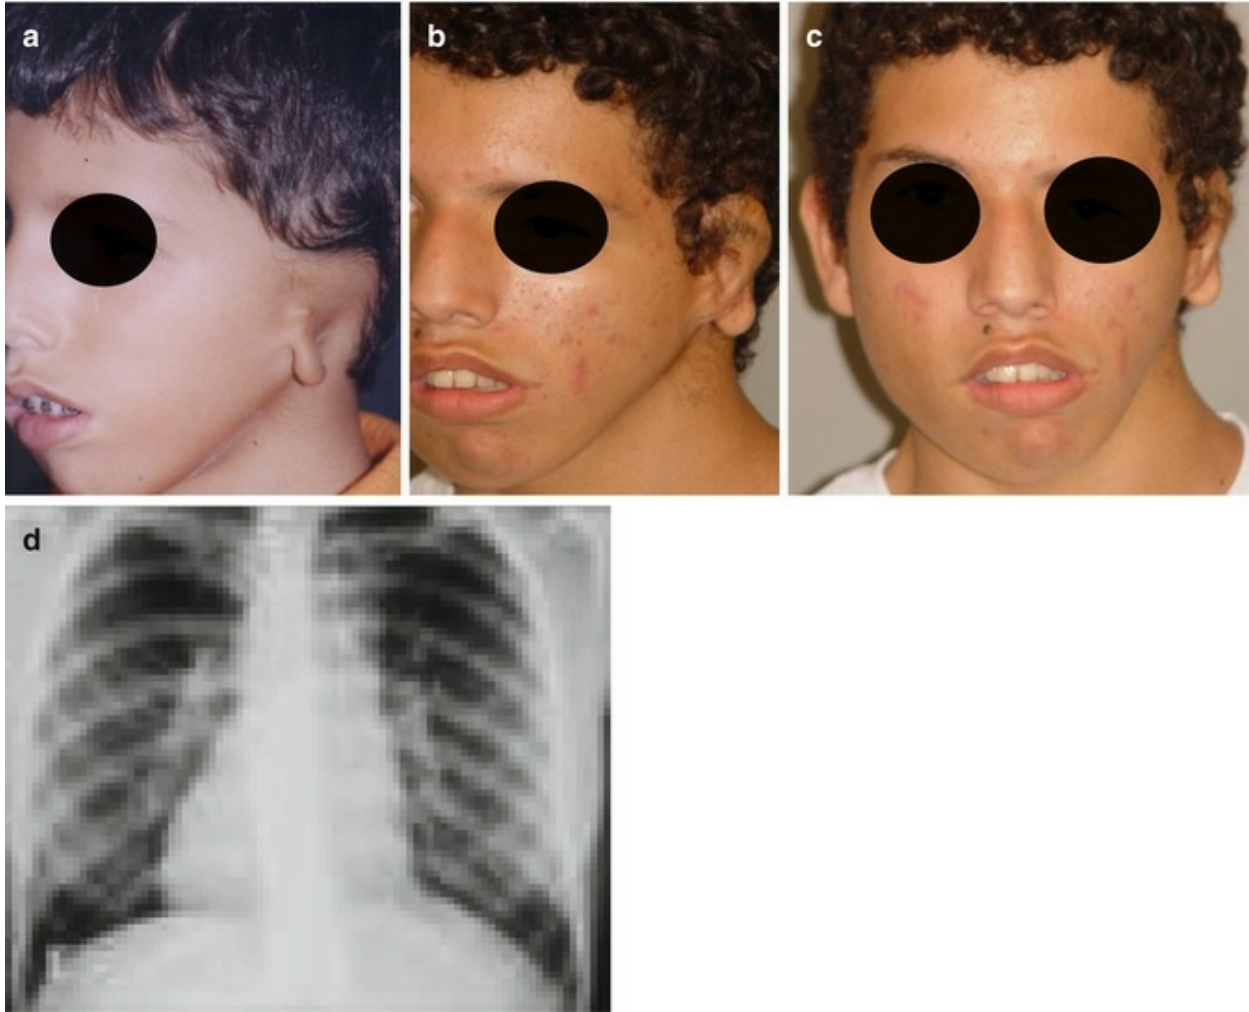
(a) An 8-year-old boy with anotia on left side, presenting with complex associated anomalies including facial asymmetry and disturbance of dental arcade and dextrocardia. (b, c) Photo of the same patient at 16 years, showing post-operative results after two stages of ear reconstruction on the left side. (d) Radiograph where dextrocardia is evident combined with situs inversus totalis
